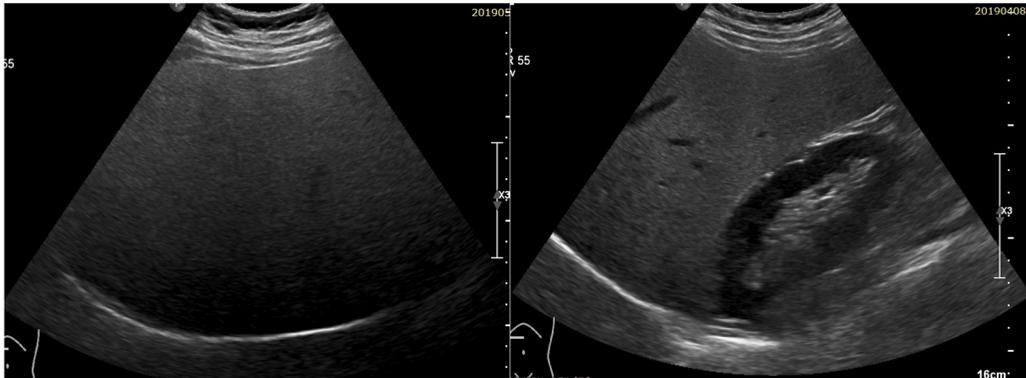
Hepatic steatosis detected by abdominal ultrasound. Hyperechoic liver with posterior ultrasound attenuation (left) and elevated hepatorenal index (right).
